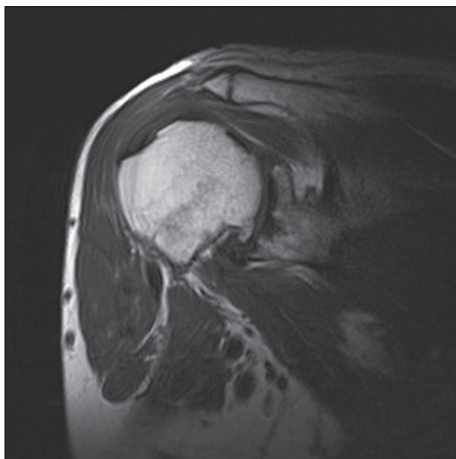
T2 weighted coronal MRI scan showing intact rotator cuff with muscle belly of normal signal and volume
